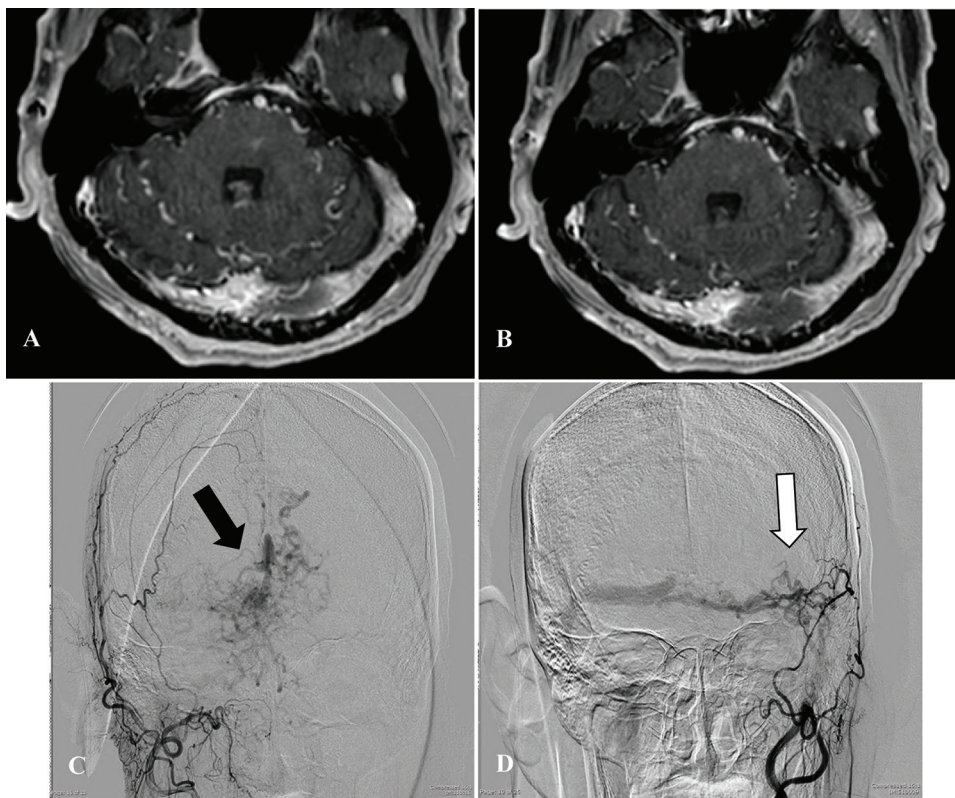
Dural AVF at the torcular herophili and left transverse sinus. (A, B) Axial 3D contrast-enhanced THRIVE MRI reveals transosseous feeding arteries and low intensity curvilinear structures in bilateral transverse sinuses and torcular herophili, suggestive of dural AVF at the bilateral transverse sinuses and torcular herophili. (C, D) DSA reveals dural AVF at the left transverse sinus (white arrow) and torcular herophili (black arrow). No dural AVF is found at the right transverse sinus on DSA.
